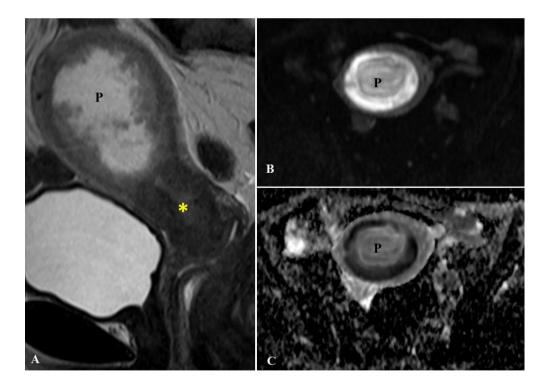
(A) Sagittal T2 weighted MRI showing mass in the cervix (yellow asterisk*) extending to lower uterine segment causing cervical stenosis and pyometra (P). Diffusion weighted MRI (B) showing hyperintense signal of pyometra which on corresponding ADC map (C) showing restricted diffusion.
